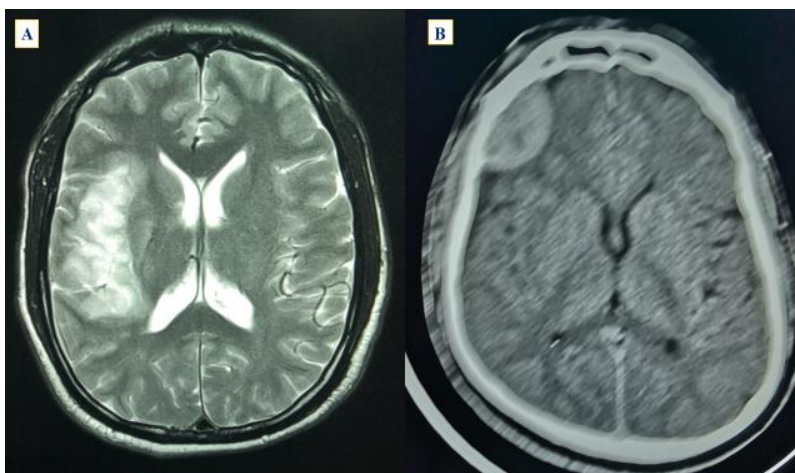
Male 59-year-old with left parietal minor EDH (epidural hematoma) after trauma: A and B axial MRI.
